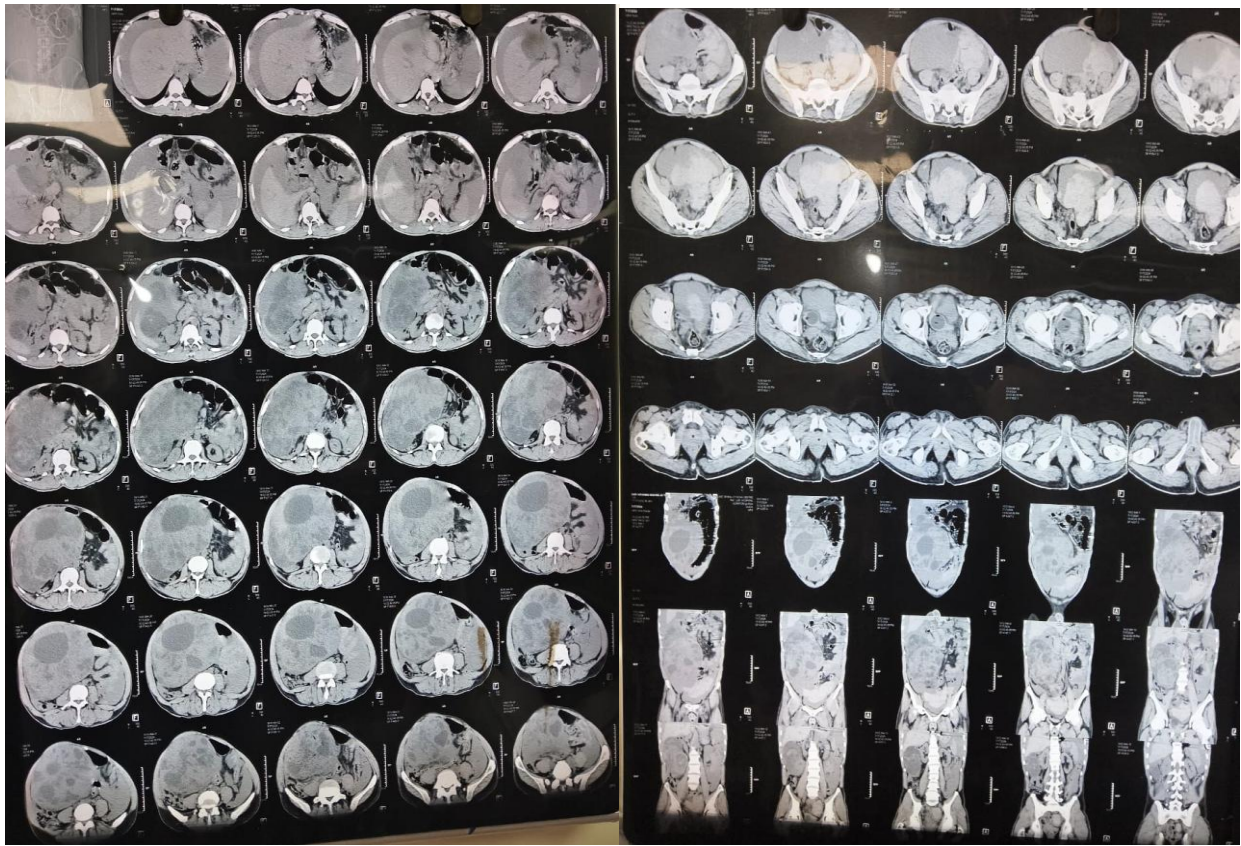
Contrast-Enhanced CT Abdomen/Pelvis
